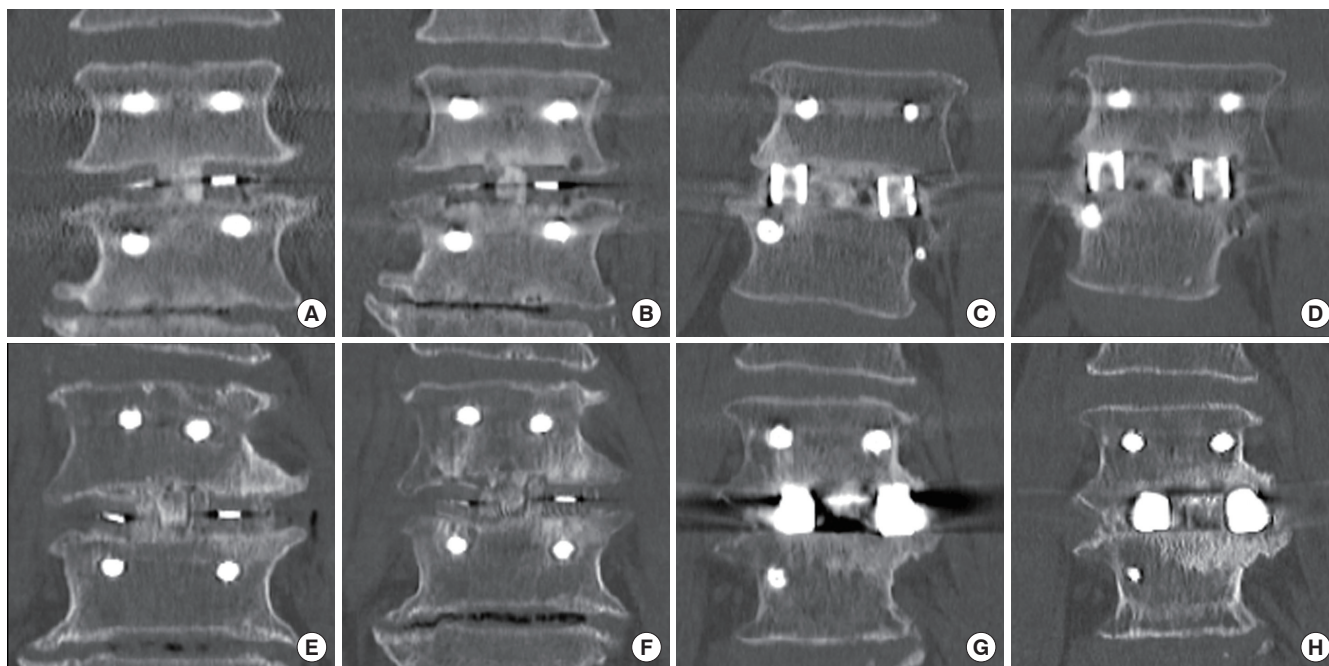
Computed tomography scans at day 0 (A, C, E, G) and 6-month (B, D, F, H) postoperation showing vertebral endplate cyst formation (VECF) around the polyetheretherketone (PEEK) cages in a 66-year-old man (A, B), the titanium (Ti) cages in a 58-year-old man (C, D), the Ti-coating PEEK cages in a 66-year-old woman (E, F) and the porous tantalum (Tn) cage in a 69-year-old woman (G, H). VECF was multiple and diffused in patients treated with the PEEK cage and the Ti-coating PEEK cage. In contrast, VECF was local and limited in numbers in patients treated with the Ti cage and the porous Tn cage.
